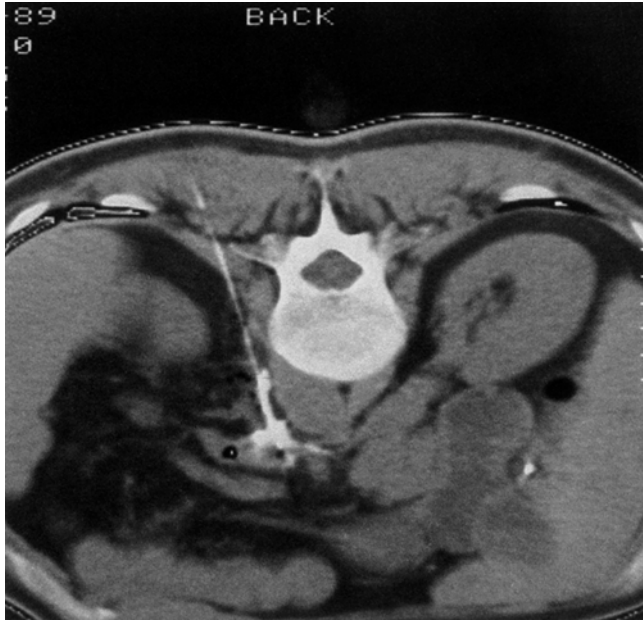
Dorsal CT-guided celiac plexus injection. After injection of contrast medium, a good spread in the area of the celiac plexus can be seen (Reproduced with permission from Danilo Jankovic)
